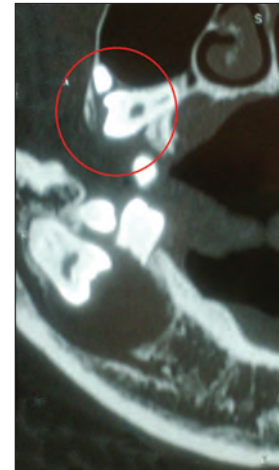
CT image shows maxillary radiolucent lesion surrounding the right impacted third molar
